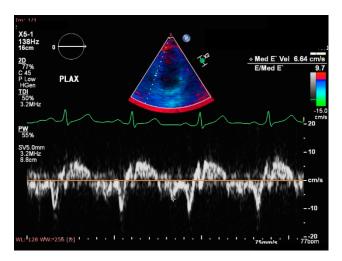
Tissue Doppler Echocardiography, four chamber view, tissue Doppler, estimation of LV filling pressures by measuring E/E'. Prepared by the authors. Courtesy of the Pediatric Clinical Hospital Sibiu, Lucian Blaga University of Sibiu.
